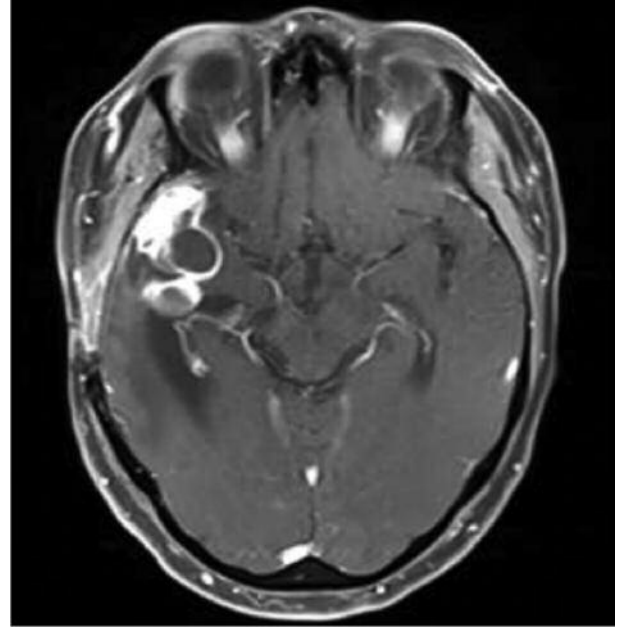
Contrast-enhanced axial brain MRI showing nodular enhancement of the right temporal lobe mass with cystic components (April 2017).
